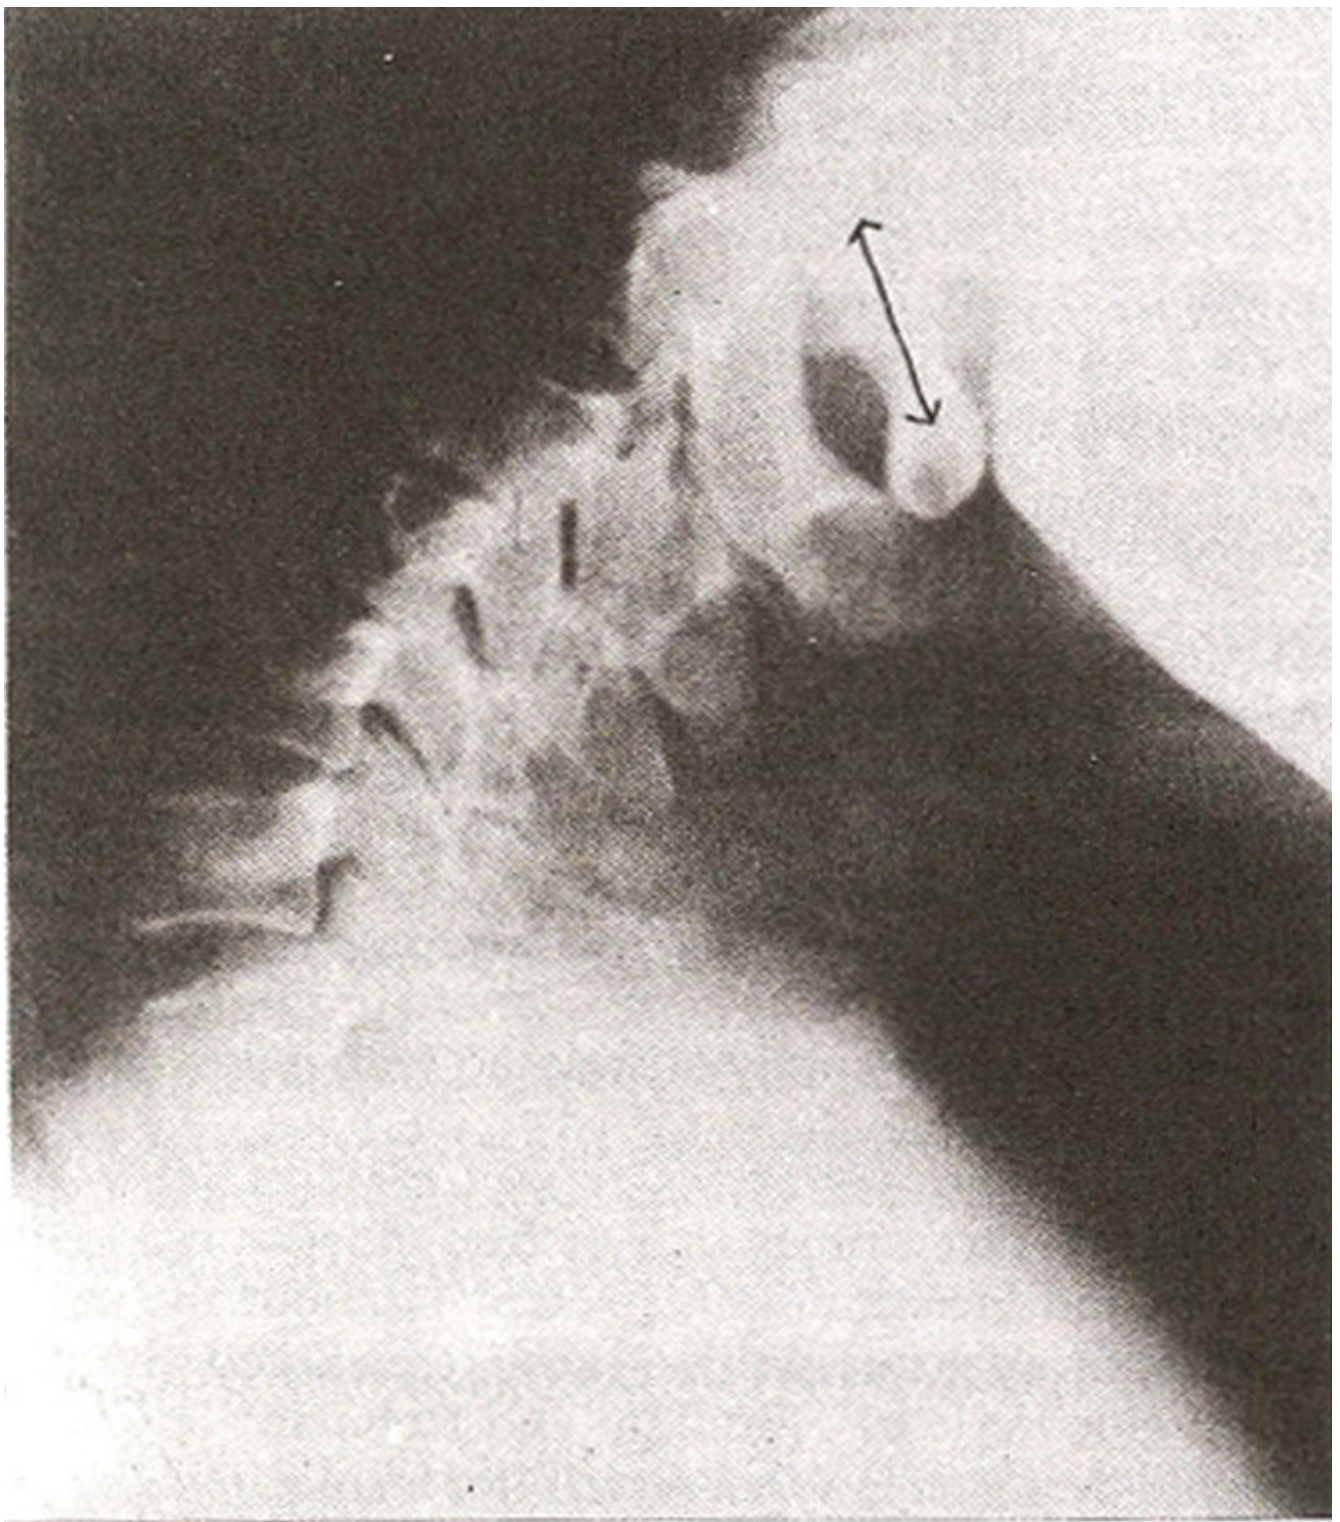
X-ray cervical spine showing normal neural canal. (See original text for further description).
